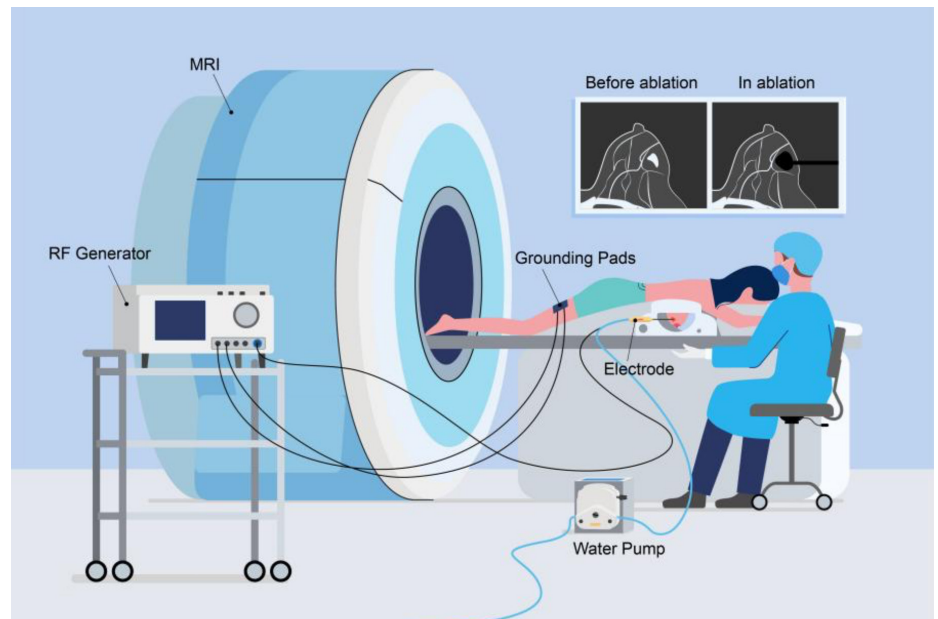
Procedure for magnetic resonance imaging radiofrequency ablation therapy for breast cancer. Patient lies prone with the breast placed on the biopsy frame with breast coil. The radiofrequency generator provides the necessary ablation energy which is applied through the needle into the tumor tissue. The water pump is utilized to adjust and maintain the temperature of the needle tip. MRI, magnetic resonance imaging.
